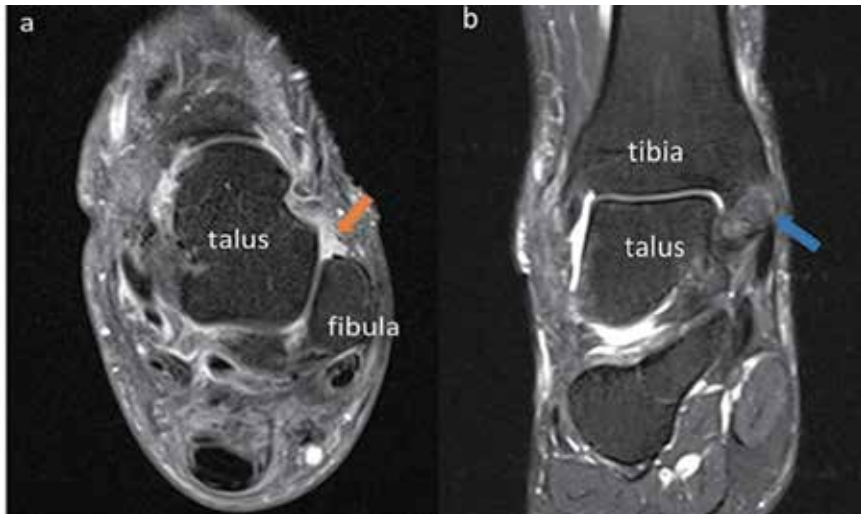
MRI of injured ankle ligaments. (a) Axial view of the left ankle. The arrow points to the absent ATFL. (b) Coronal view of the right ankle. The arrow points to the injured deep deltoid ligament along with bone marrow edema in the medial malleolus.
